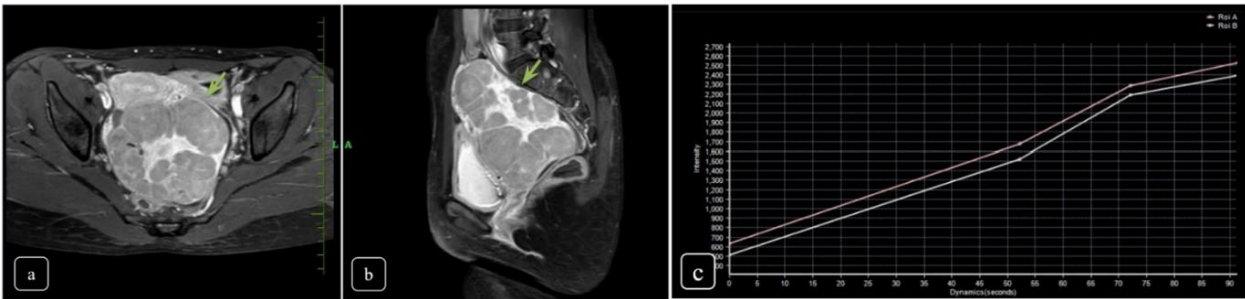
T1 Post contrast axial (a) and sagittal (b) show heterogenous enhancement with mild peripherally enhancing smooth lobulated thin margins (c) Dynamic contrast enhancement shows a high intensity curve for an MRI ORADS score – 5 (HPE Diagnosis – Dysgerminoma)
